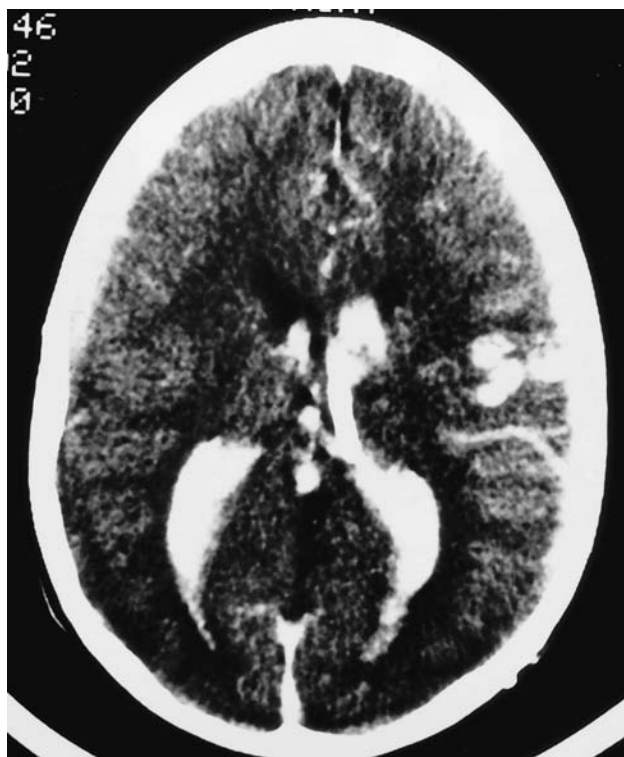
This CT scan outlines intraventricular and subcortical blood in the left hemisphere. A serpentine enhancing vessel is shown in the anterior parietal region. This study does not confirm whether it is arterial or venous.
